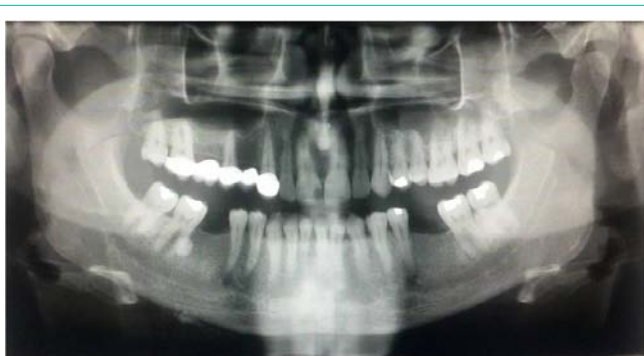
Panoramic radiograph depicting the multiple radio-opacities along the periosteal surface.
